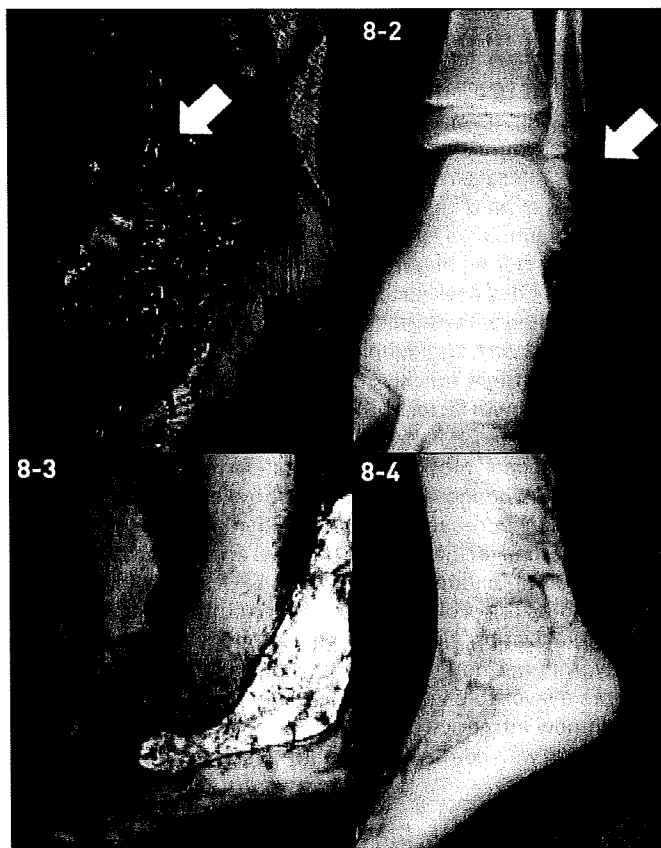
Case 1. The patient had a left ankle skin defect measuring 30 x 10 cm, and a 5 x 3 cm bone-exposed area was observed (arrow). Figure 8-2. An X-ray revealed fracture and bone defect of the fibula (arrow). Figure 8-3. Application of artificial dermis over the entire wound was performed. Figure 8-4. One year after surgery. The wound had been completely resurfaced and maintained without relapse, ankle joint contraction, and hypertrophic scar formation.
